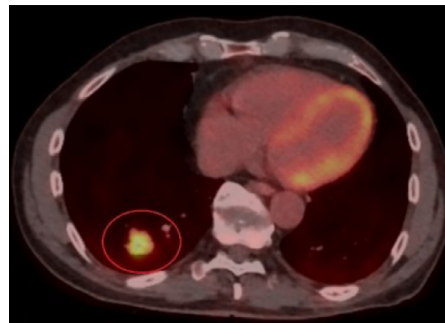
PET/CT showing FDG-avid nodule in right lower lobe, circled in red. Nodule SUV max 7.0; background mediastinal blood pool SUV max 2.1.
